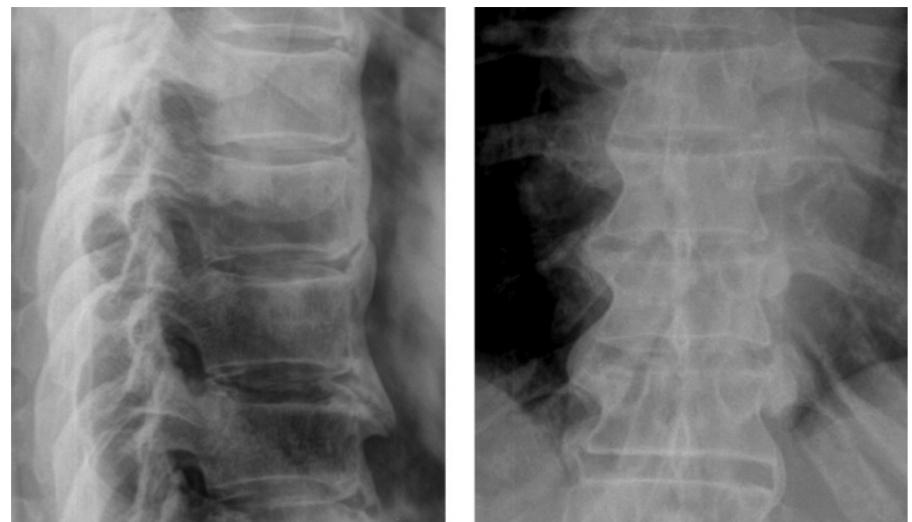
Plain radiographs of diffuse idiopathic skeletal hyperostosis (DISH) affecting the thoracic spine. Source: Courtesy of Dr Anthony Doyle.
